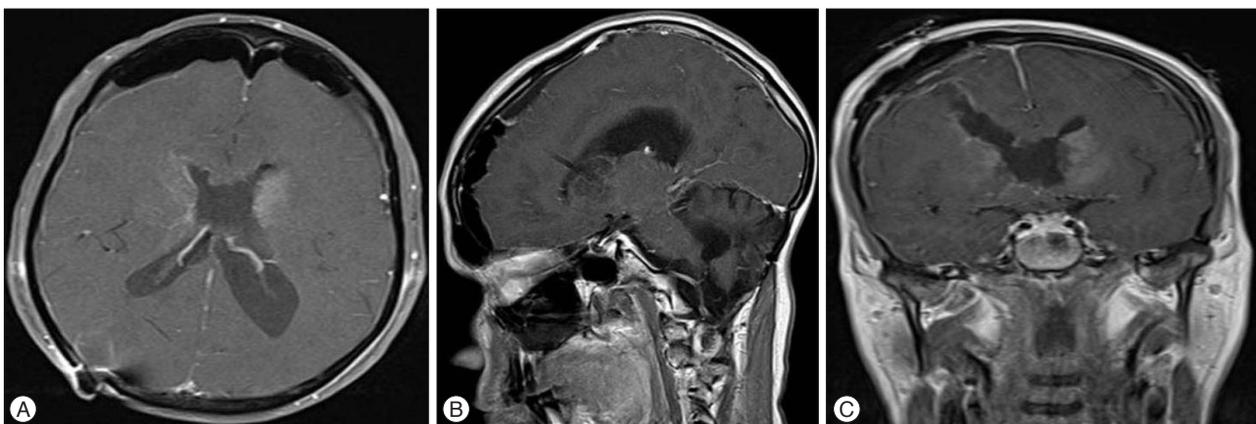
MRI with contrast axial (A), sagittal (B), and coronal (C) showing right transcortical intraventricular approach for tumor resection. Gross tumor resection was accomplished.
